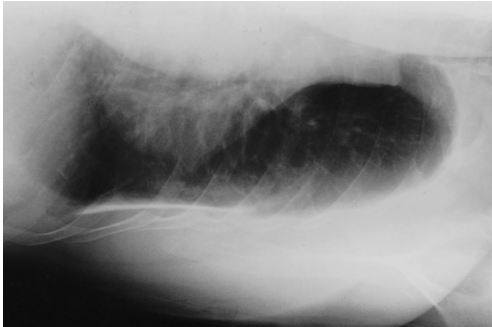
Left lateral decubitus radiograph clearly shows a flat pleural thickness with calcified plaque on the visceral pleura.
